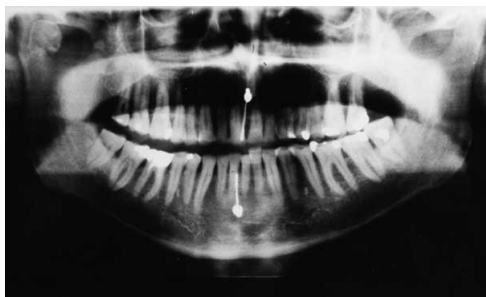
X-ray OP postoperative with hypomochlion in place
